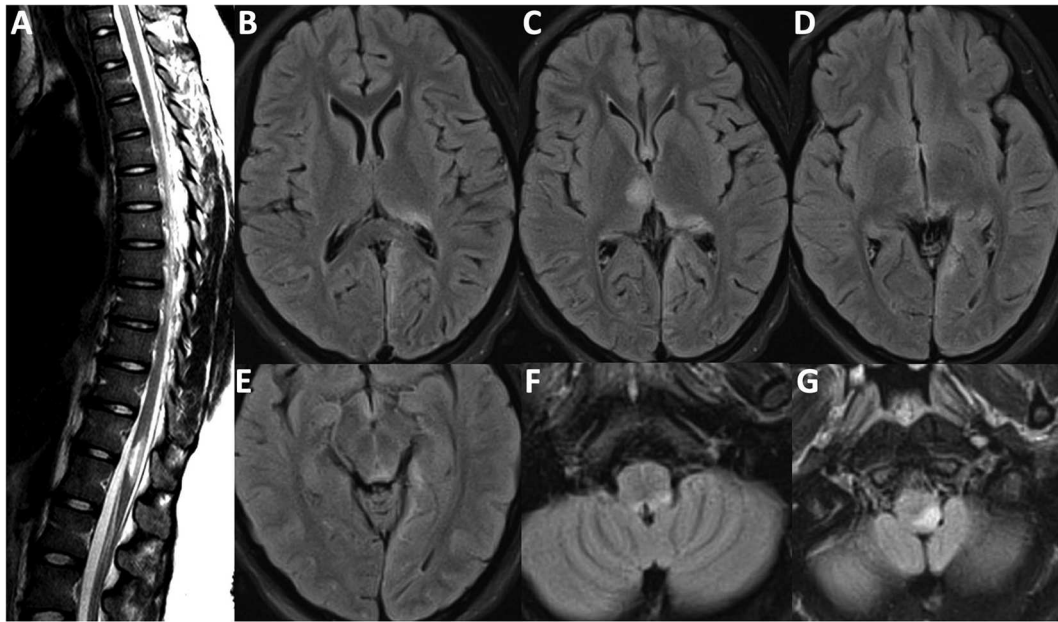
MRI Brain-FLAIR sequence from first attack in 2012. (A) Short segment transverse myelitis at T11/T12 vertebral segment with mild cord expansion. Lesions depicted affecting the (B) left posterior thalamus and the subcortical/juxtacortical white matter of the left medial occipital lobe; (C) right anterior thalamus and pulvinar region of the left thalamus; (D) highlighting left medial occipital lobe involvement; (E) periaqueductal gray matter hyperintensity; (F) left dorsal medullary hyperintensity also depicted in (G).
